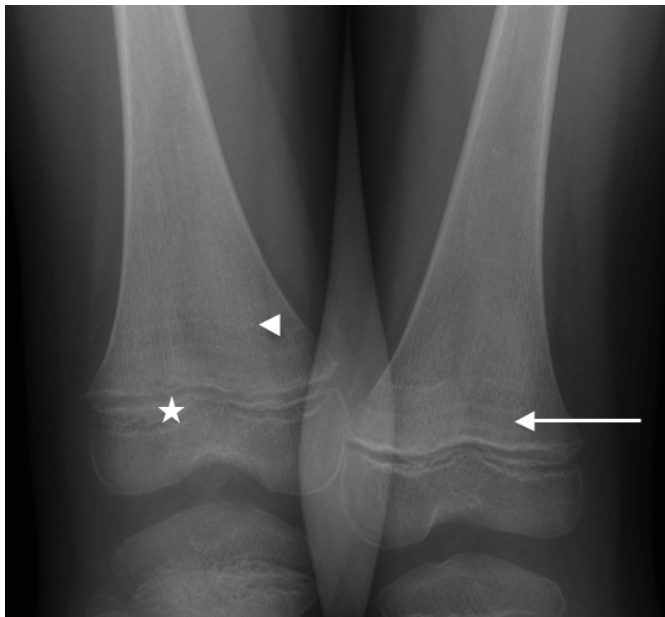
Lower limbs X-ray showing Trummerfeld zone (arrow), Frankel's lines (arrow head) and enlarged metaphyseal margin (star)
